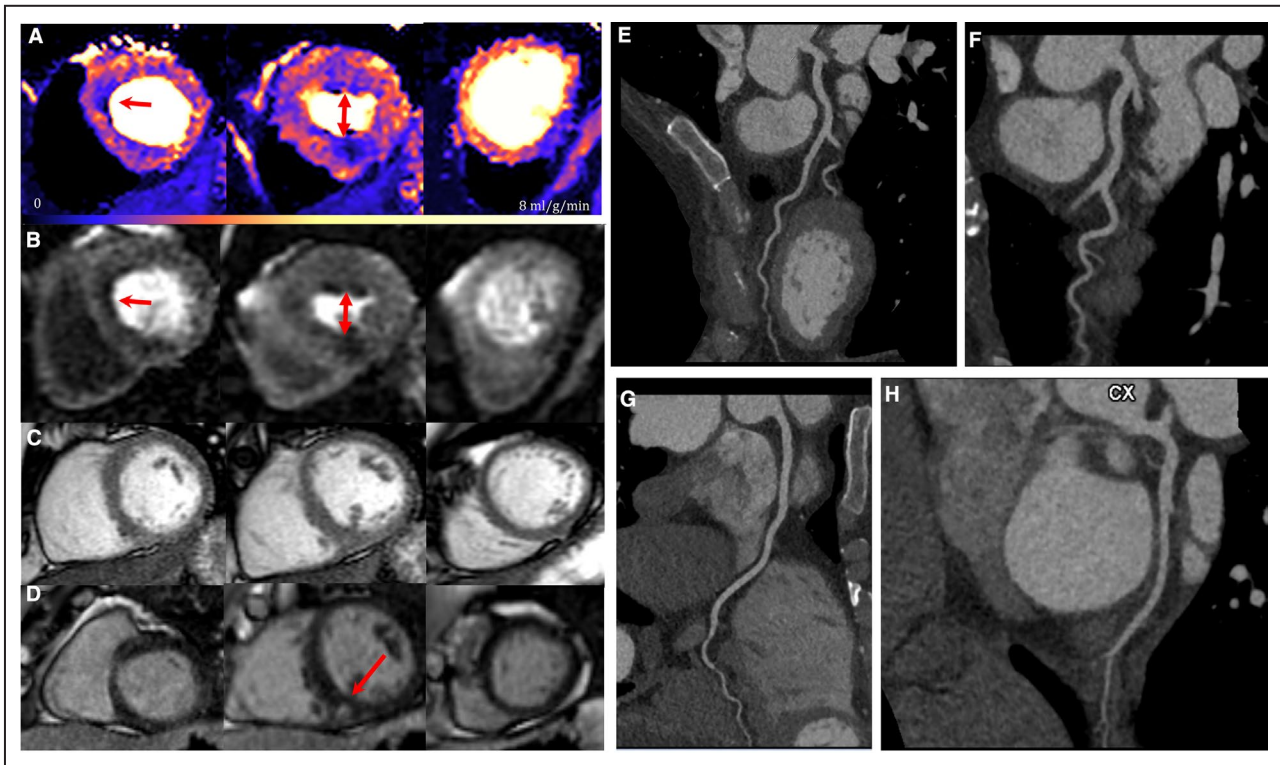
Basal septal and mid-right ventricular insertion point significant perfusion defects in genotype-positive; left ventricular hypertrophy-negative with minor inferior right ventricular insertion point late gadolinium enhancement and normal computed tomography coronary angiogram.
